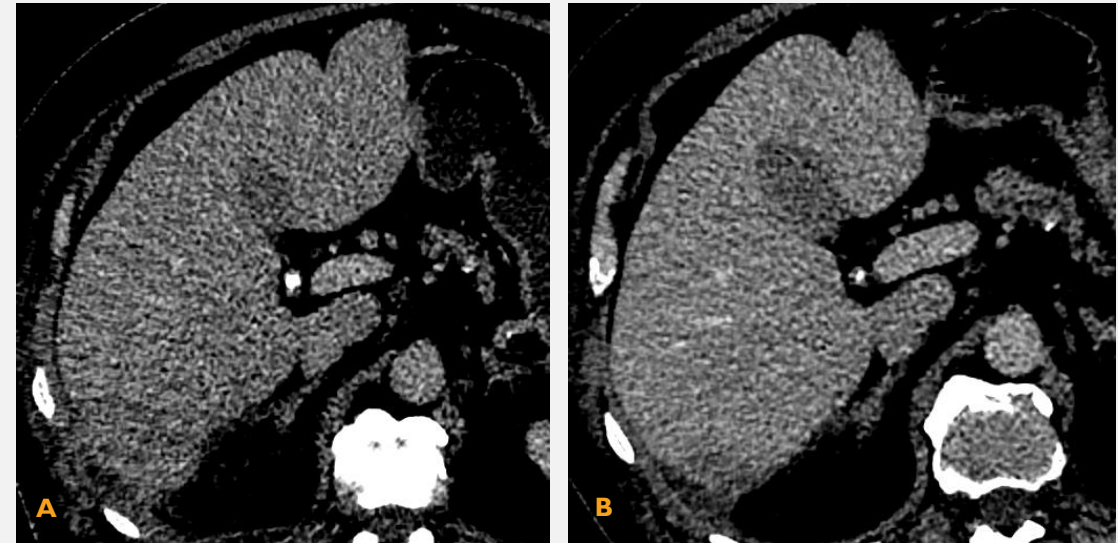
Initial portovenous phase CT shows showed a large solitary hypodense focal liver lesion and no other suspicious lesions (A). Follow up CT demonstrated interval decrease in size (B).
